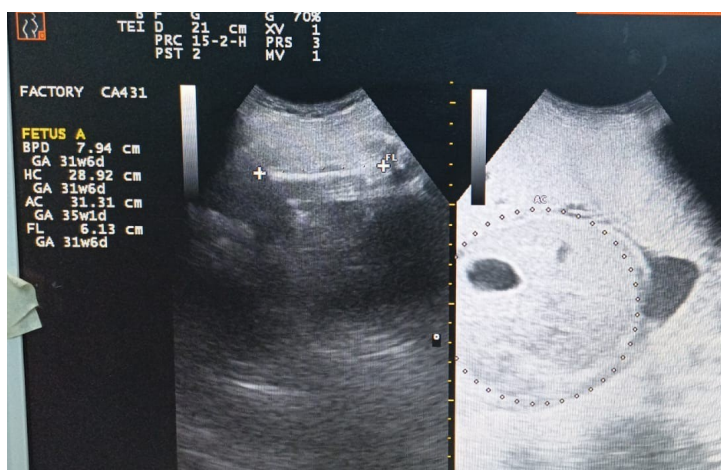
ultrasound suggested of intraabdomen organomegaly of fetus
